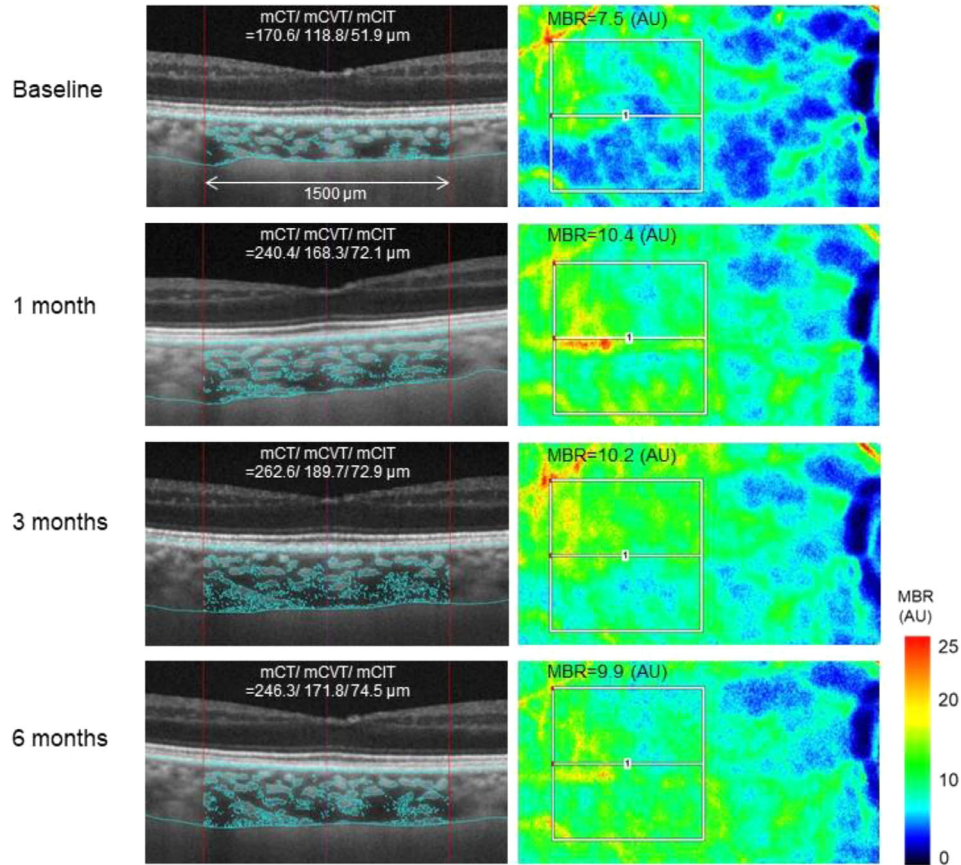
Representative OCT and LSFG images in the macula of the same eye at different time points. (Left) Horizontal OCT b scan images showing the area of CT measurements (width of 1500 μm centered on the fovea). The demarcated regions represent the choroidal stromal area, and the area outside the demarcated regions represents the choroidal vascular area. (Right) Color-coded MBR maps of LSFG. Square measurement regions (300 \times 300 pixels) were set in the central macula. Measurements in postoperative OCT and LSFG images were performed at the same retinal location as the baseline. The mCT in both mCVT and mCIT and MBR increased at all postoperative time points.
